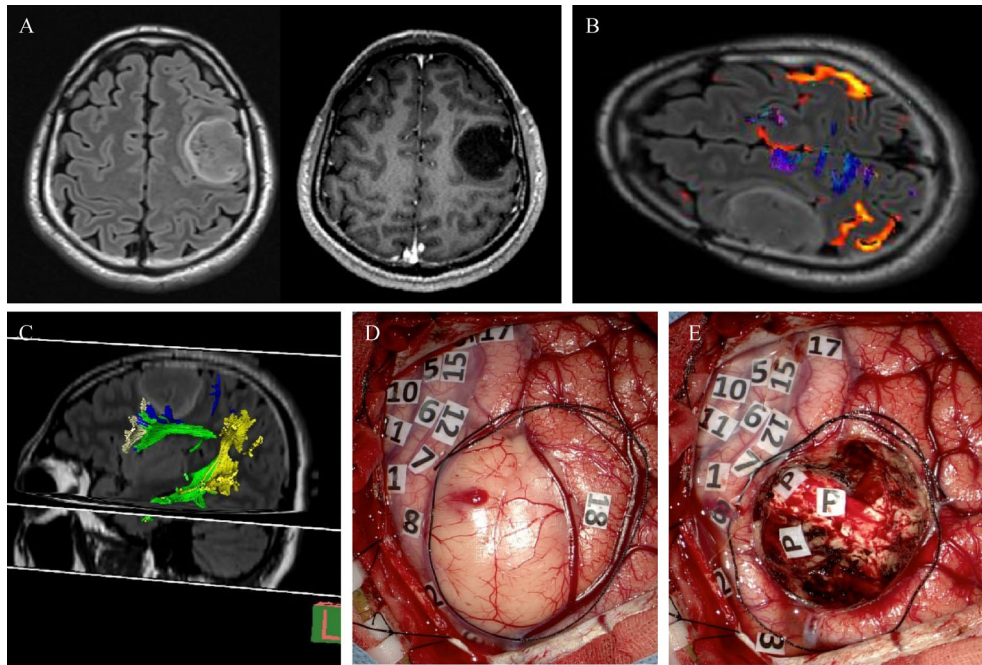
A case of left middle frontal gyrus low-grade glioma. (A) T2-flair imaging and enhanced T1 MRI imaging show the tumor located at the left middle frontal gyrus without enhancement. (B) Functional MRI shows the bold signal of motor- and language-related cortices. (C) DTI shows the language-related tracts. The green fiber is the arcuate fasciculus, and the white fiber is the Aslant tract. (D) Cortical mapping before tumor resection. Tag 17 shows the anomia site. Tag 18 is the hesitation site of the anomia. Tag 15 shows the speech arrest site. Tags 7, 8, and 12 show the cortex related to lip and jaw movements. Tags 2 and 3 show the hand motor-related cortex. (E) Cortical and subcortical mapping after tumor resection. P tags show the subcortical cerebrospinal fibers. Tag 18 is a hesitation functional site of speech impairment, and the middle frontal gyrus is not a typical language-eloquent site. The area is resected to obtain a good resection rate of the tumor.
